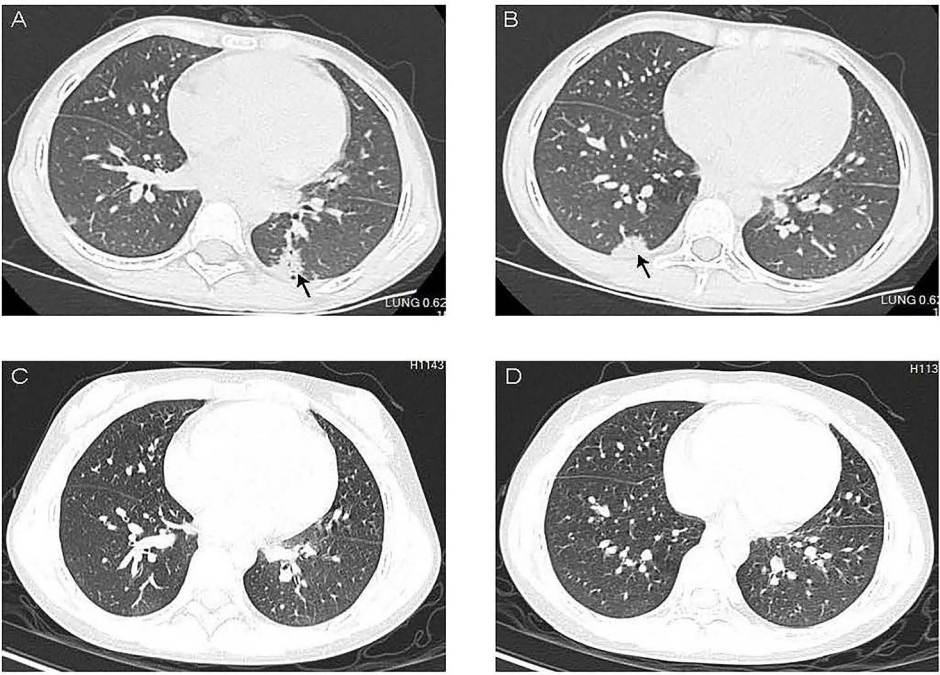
Chest CT of the patient. (A and B) Chest CT of the patient at first time, showing bilateral pulmonary lesions (black arrows). (C and D) Chest CT of the patient after immunotherapy with significant improvement.
